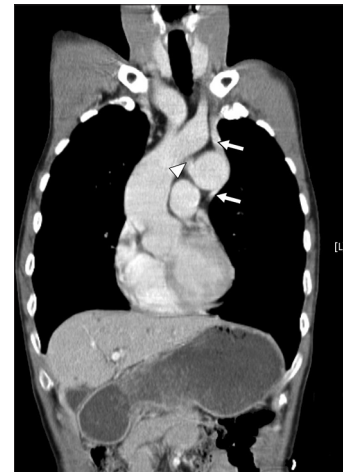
Contrast-enhanced coronal computed tomography image demonstrates the persistent left superior vena cava (white arrows) and the coarctation connecting from the tubular arch hypoplasia (white arrowhead)
